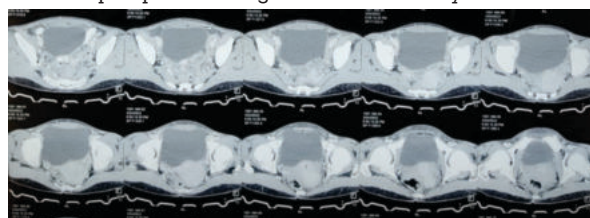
CT scan Showing Cystic lesion from bladder dome till umbilical area with subcutaneous extension. Given the above findings and the acute presentation, the patient underwent emergency exploration after informed consent. A vertical elliptical skin incision was made over the swelling after entering subcutaneous plane 15 ml pus drained and exploration was done, which revealed a 6-cm sized pus-filled cavity connected to the bladder dome by a fibrotic band.(Figure 3) The abscess with its wall and the entire tract extending to skin and bladder were excised, and the skin was closed primarily after leaving a drain.
